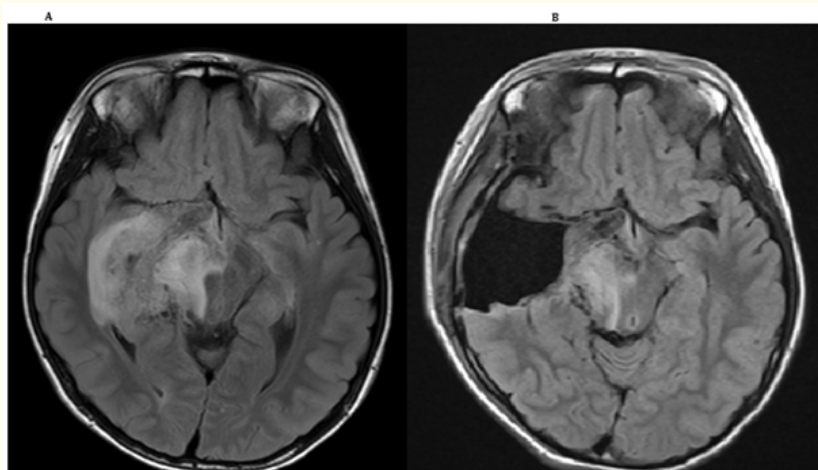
A. Magnetic resonance imaging (MRI) revealed a tumor expanding into the midbrain, right thalamus, and right medial temporal lobe.
